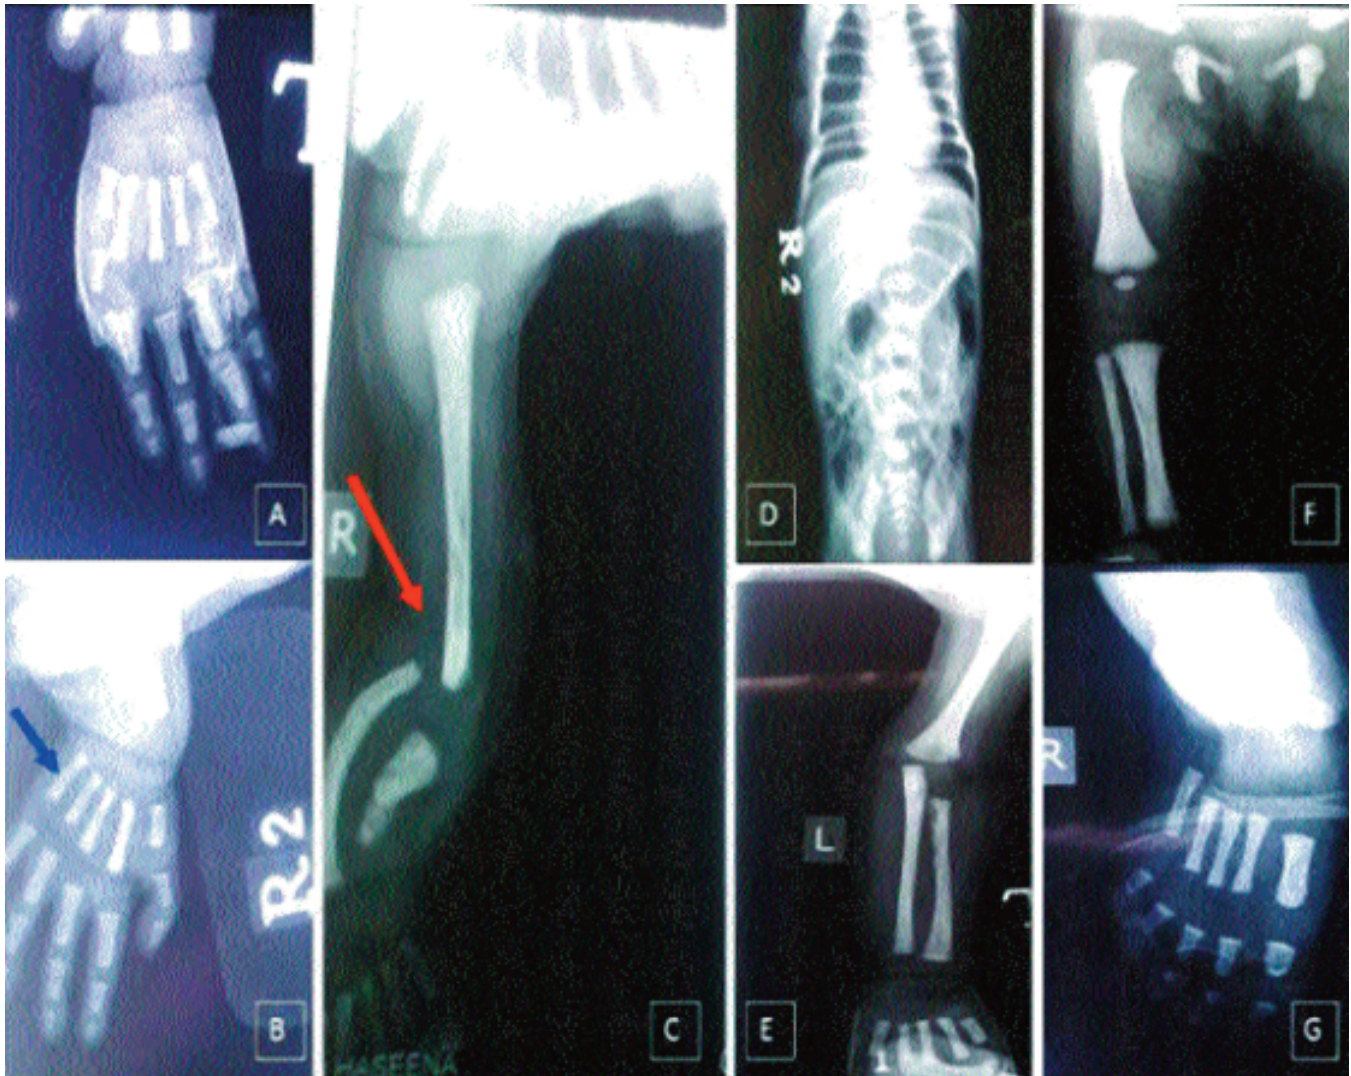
(A-G) Generalized increase in bone density was noted in all X-rays. X-ray of right forearm and hand revealed short and deformed radius and ulna (red arrow) and short right 5th metacarpal bone (blue arrow).
